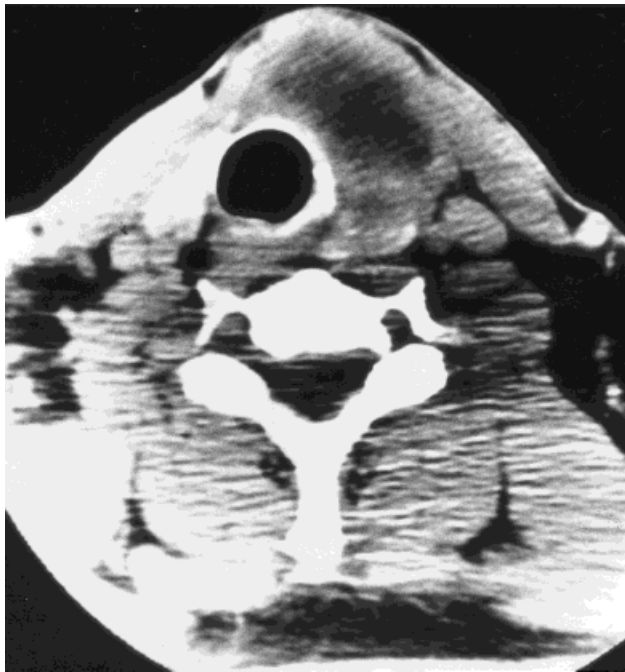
Case 3. Computed tomography image of thyroid mass, with tracheal compression and deviation.
